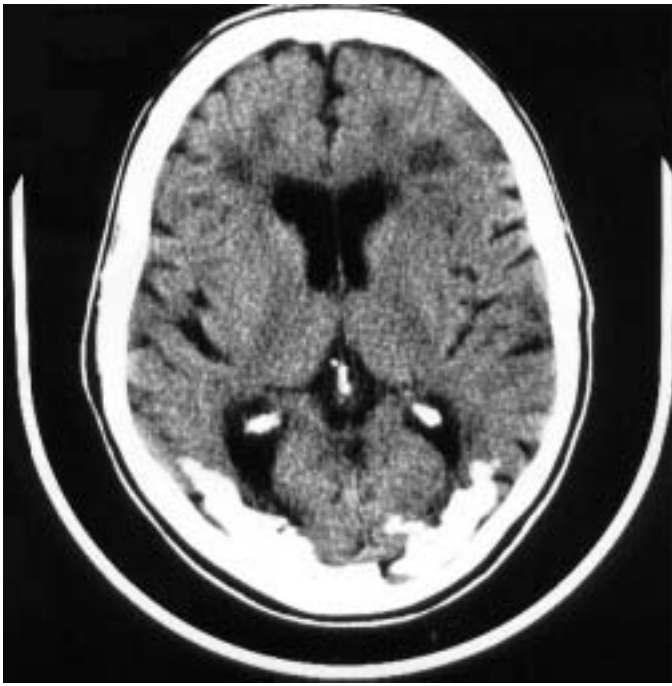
CT of the brain showing bilateral occipital calcifications in a patient with coeliac disease and epilepsy. Reproduced courtesy of Dr G. Plant, National Hospital for Neurology and Neurosurgery, Queen Square, London.
